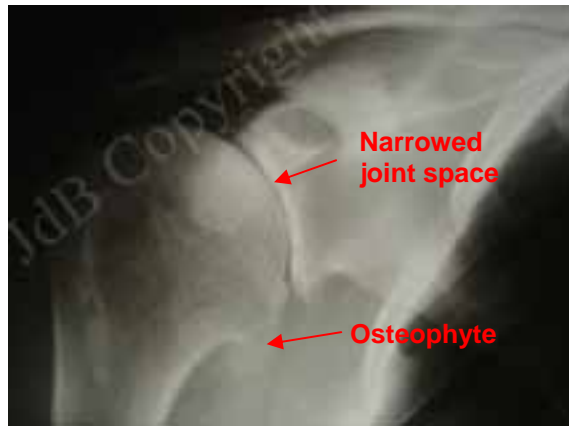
X-ray of an osteoarthritic shoulder joint- the narrowed joint space and osteophyte can be seen
